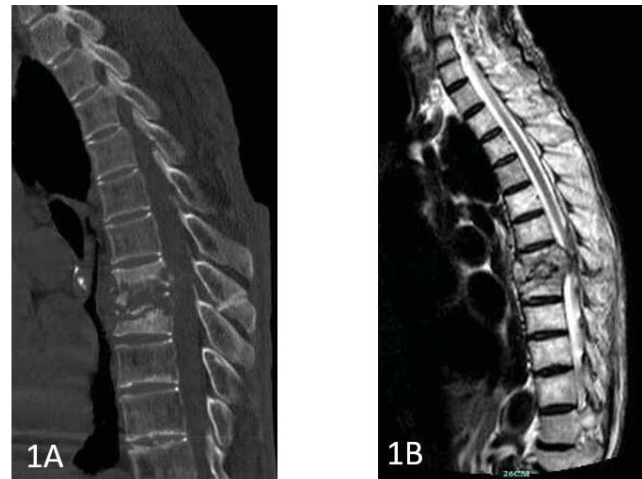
(A) Sagittal CT scan showed vertebral bone and disc destruction at the level of T7-8. (B) The spinal cord was compressed on MRI.
